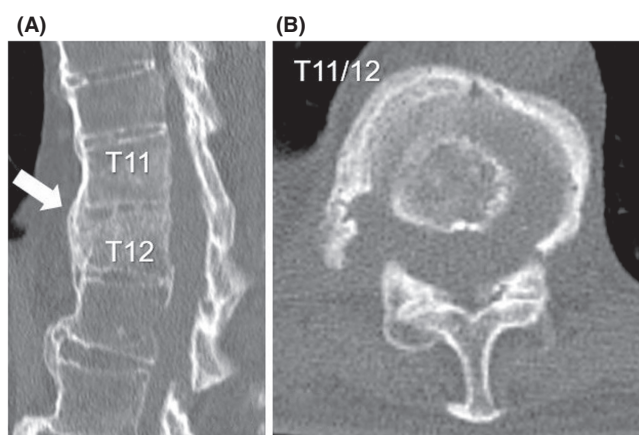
Computed tomograms at initial visit to our department; (A) sagittal section, (B) axial section. The arrow indicates ankylosed vertebral bodies by ossification of anterior longitudinal ligament between T11 and T12 without remarkable bone destruction.
